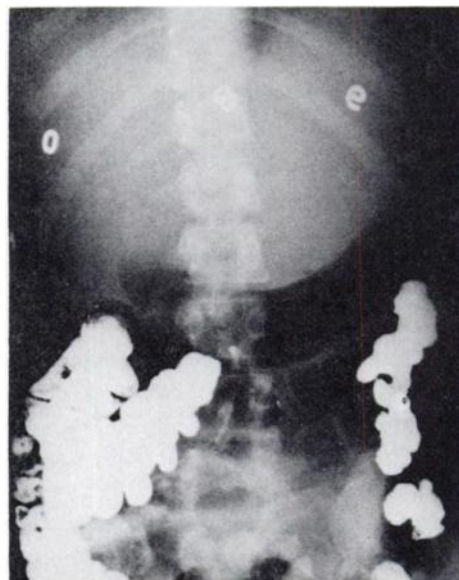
Abdominal radiograph recording enlarged lobe of liver producing extrinsic pressure on lesser curvature of stomach.
